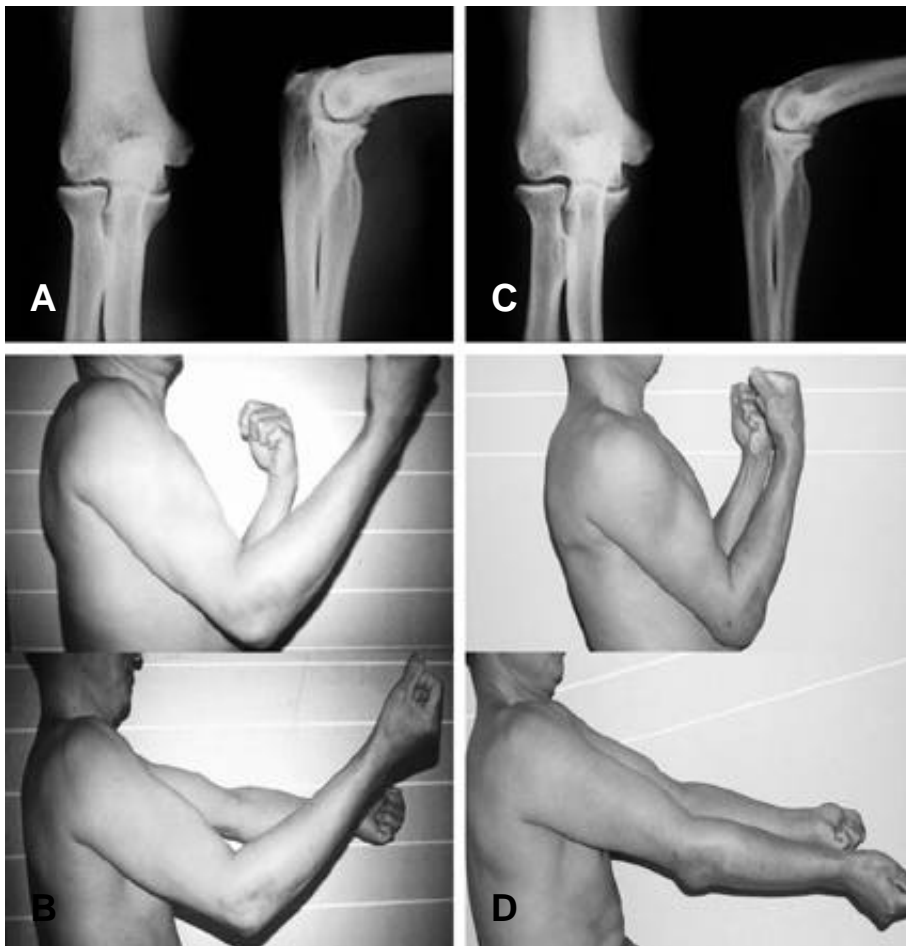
(A) Preoperative AP and lateral radiographs in a 43-year-old male with painful stiffness of right elbow joint. (B) Preoperative photographs of flexion and extension of the right elbow demonstrates a decreased range of motion (30-110 °). (C,D) postoperative AP and lateral radiographs (3-C) and photographs of flexion and extension of the right elbow (3-D)(5-140 °) 14 months after operation (anterior and posterior capsular release, synovectomy, osteophyte removal).
